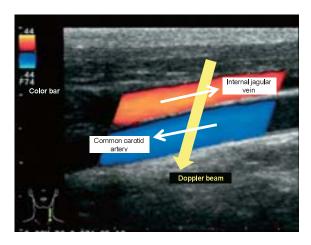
Representation by color Doppler method (left: the distal side)
